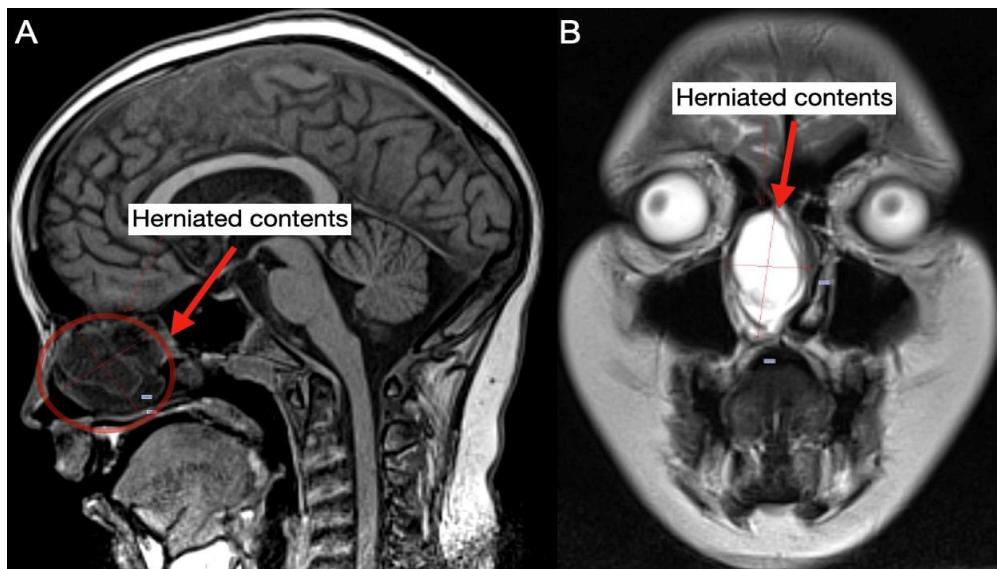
(A) Sagittal t1-weighted MRI showing the herniated contents of the roof of the nasal cavity; (B) coronal t2-weighted MRI showing the herniated contents within the middle turbinate.
